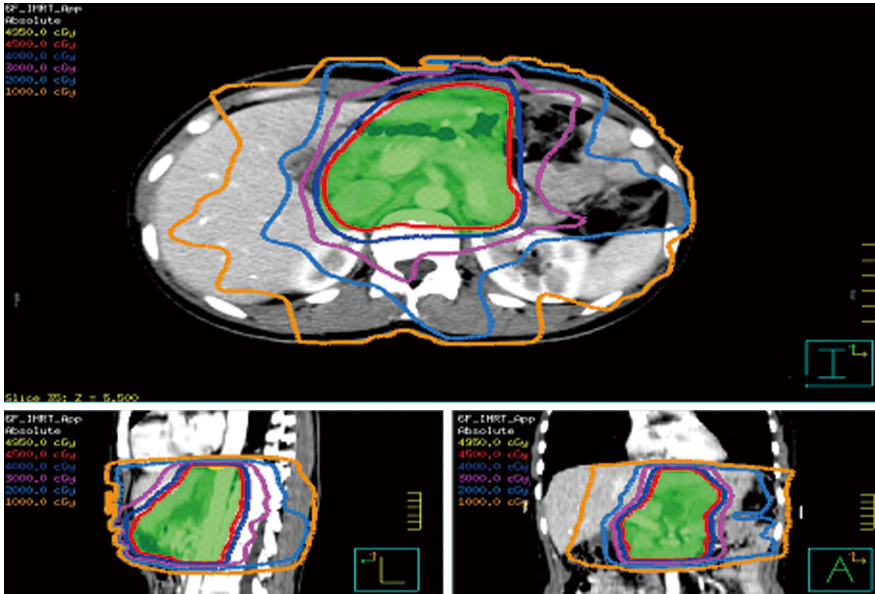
Distribution of 6-field intensity modulated radiotherapy plan. Isodose distributions are shown in three orthogonal planes through the middle of the planning target volume (PTV). The isodose levels are shown colored lines over the computed tomography images, with the green area indicating the PTV.
